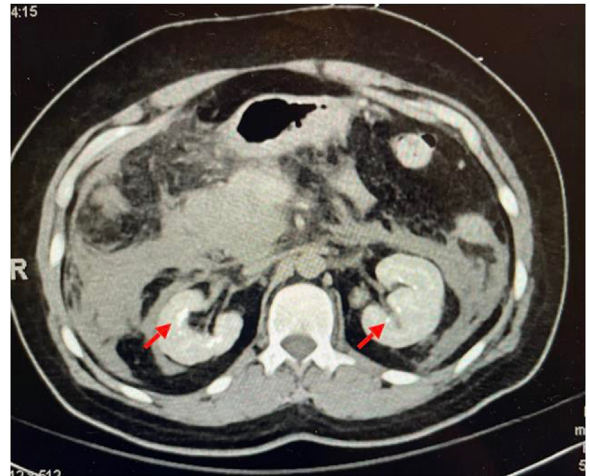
CT Abdomen/Pelvis without contrast revealing nephrocalcinosis (red arrows) as well pancreatitis.
